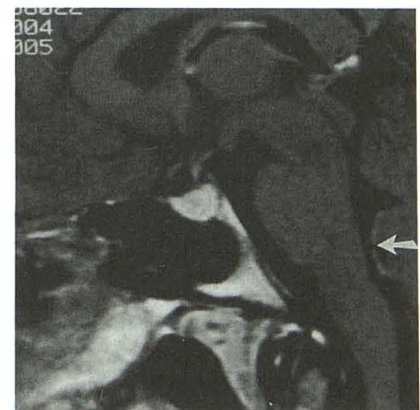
Sagittal T1-weighted MR image, SE 600/20, obtained after administration of contrast material shows enhancement in choroid plexus (arrow) just ventral to inferior medullary velum, separate from region of area postrema as seen in Fig. 1B.
